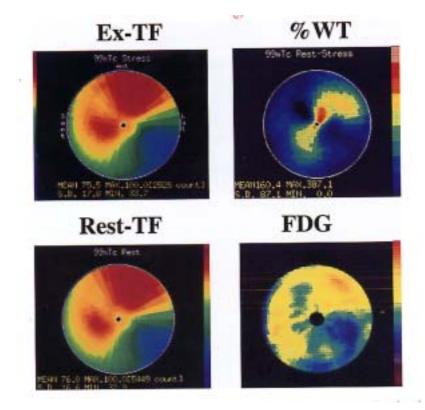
A 67-year-old male patient with previous posterior wall myocardial infarction (see text). *Left*, polar map of % uptake of Ex/rest TF. *Right upper*, polar map of %WT. *Right lower*, polar map of % uptake of FDG.
